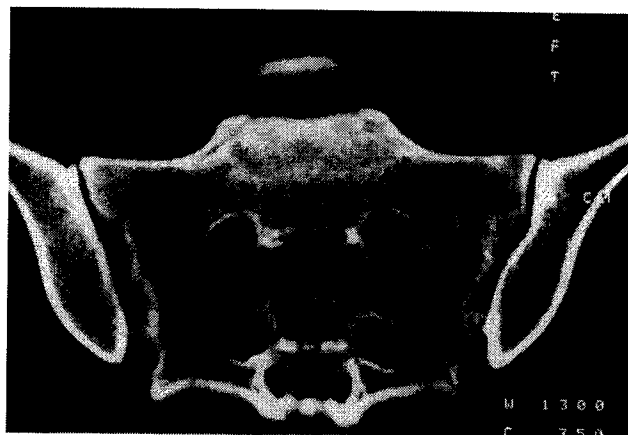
A coronal image CT scan of the pelvis in case 2, performed 5 weeks after injury, reveals an irregular oblique line of increased attenuation coursing through the superior portions of the left sacral ala (arrow).
